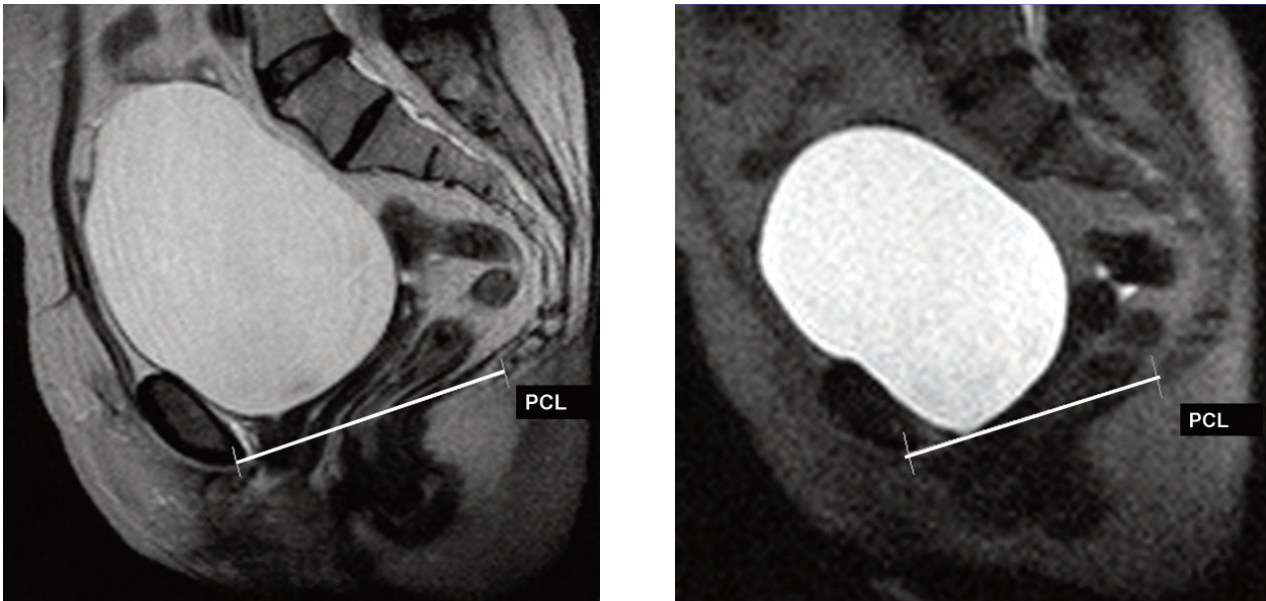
A 53-year-old postoperative mild symptomatic woman (the severity score of incontinence, 6). Sagittal T2-weighted MR image at rest (A) and sagittal modified T2-weighted MR image on maximal straining (B), showing minimal bladder neck descent (PCL: pubococcygeal line).
